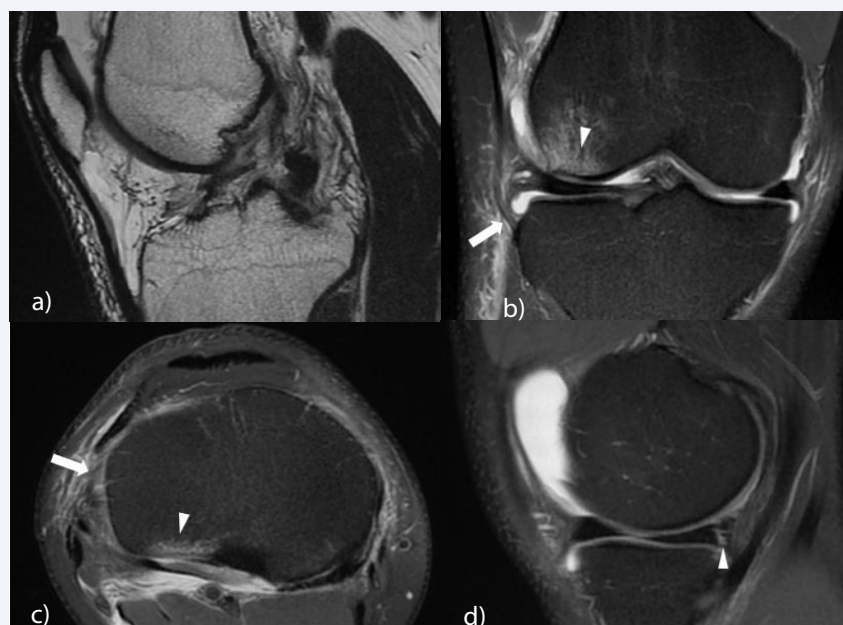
Associated injury of the anterolateral ligament (ALL) and medial meniscus (A) Oblique sagittal T2-weighted image shows a complete tear of the ACL at the mid-substance. The proximal stump appears vertical to the Blumensaat line, whereas the distal stump appears horizontal. (B) On coronal fat-suppressed proton density-weighted image, the ALL shows increased signal intensity near the tibial attachment (arrow) and periligamentous edema, indicating injury of the ligament. Bone contusion is also noted at the lateral femoral condyle (arrowhead). (C) Axial fat-suppressed proton density-weighted image shows increased signal intensity of the anterolateral ligament (arrow) and bone contusion at the posterior aspect of the lateral tibial plateau (arrowhead). (D) A vertical longitudinal tear is noted at the posterior horn of the medial meniscus.
